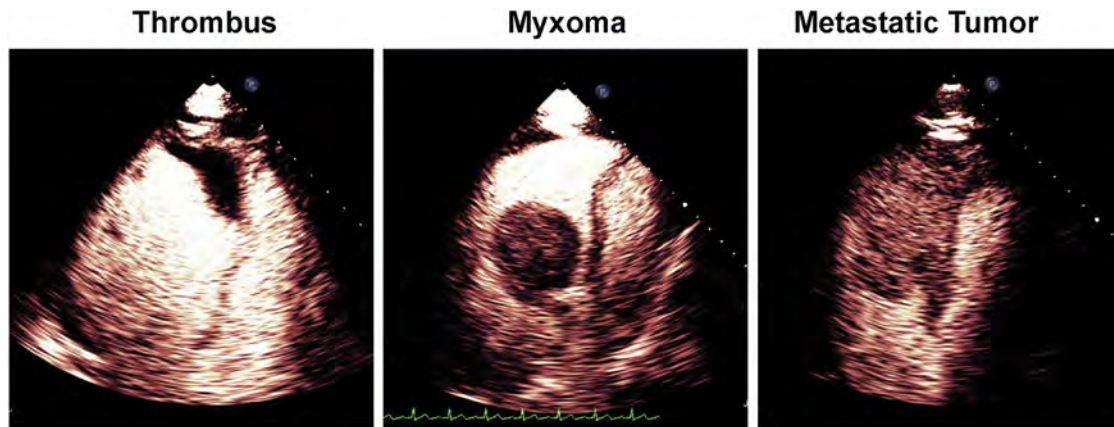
Modified apical four-chamber images of intracardiac masses in patients receiving continuous UEA infusion. All images were obtained at plateau intensity before a high-MI impulse. The *left panel* exhibits no enhancement, consistent with thrombus. The *middle panel* exhibits a small amount of enhancement (less than myocardial) and was a myxoma. The mass in the right ventricle in the *right panel* was hypervascular (similar to myocardial plateau enhancement) and was a metastatic renal cancer (see [Video 5](#); available at www.onlinejase.com).
